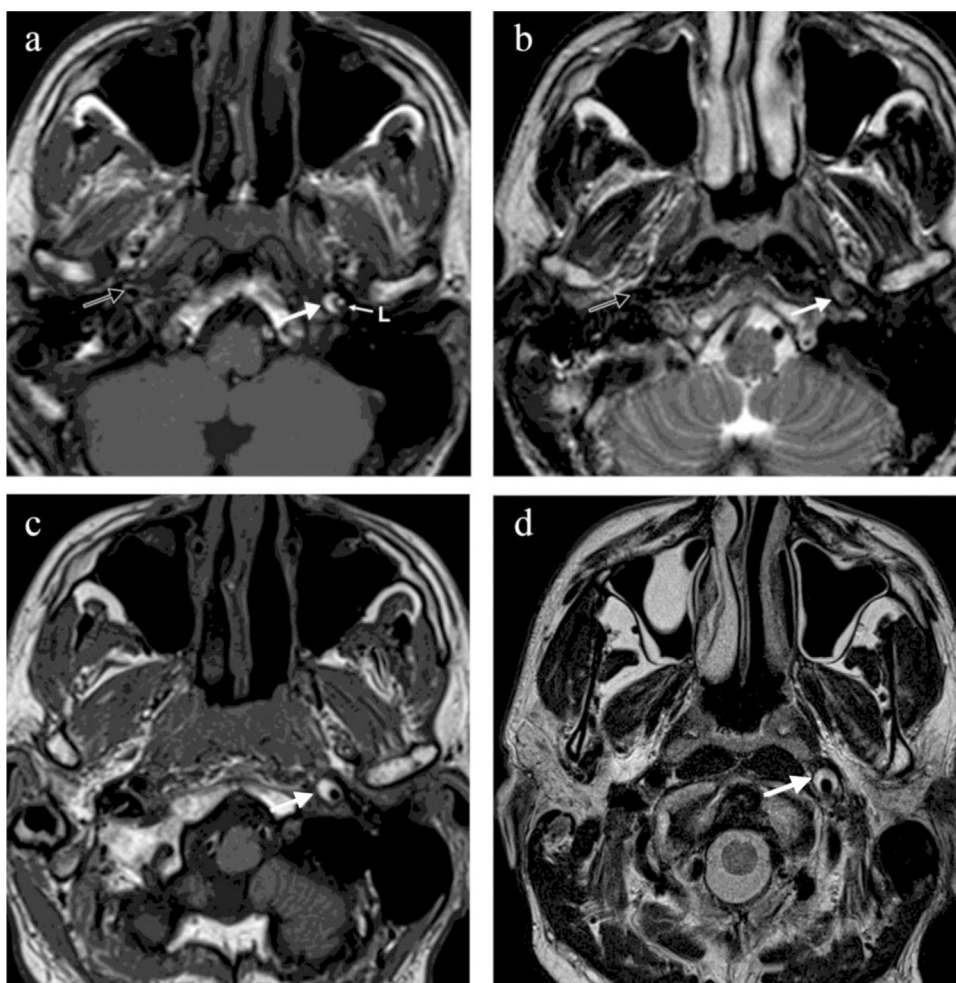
Evolution of the dissection in MRI scans. Admission MRI shows intramural hematoma (white arrow) in LICA in a subacute phase with a high signal on T1 (a) and intermediate on T2 (b). The artery is extended, however its lumen (L) is substantially narrowed. Increased signal in the lumen of the artery indicates slow flow. RICA (black narrow) has a low T1 and T2 signal caused by flow void artifact. Follow-up MRI (c and d) after 15 weeks revealed the transition the hematoma (white arrow) to a chronic phase with a high signal on T1 (c) and T2 and normalization of the lumen of the artery.
